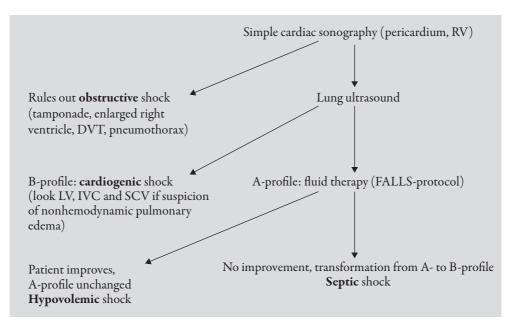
Falls protocol. DVT = deep vein thrombosis; LV = left ventricle; IVC = inferior vena cava; SCV = superior caval vein. From Figure 2, Lichtenstein DA. Fluid administration limited by lung sonography: the place of lung ultrasound in assessment of acute circulatory failure (the FALLS-protocol). Expert Rev Respir Med. 2012;6(2):155–162.
